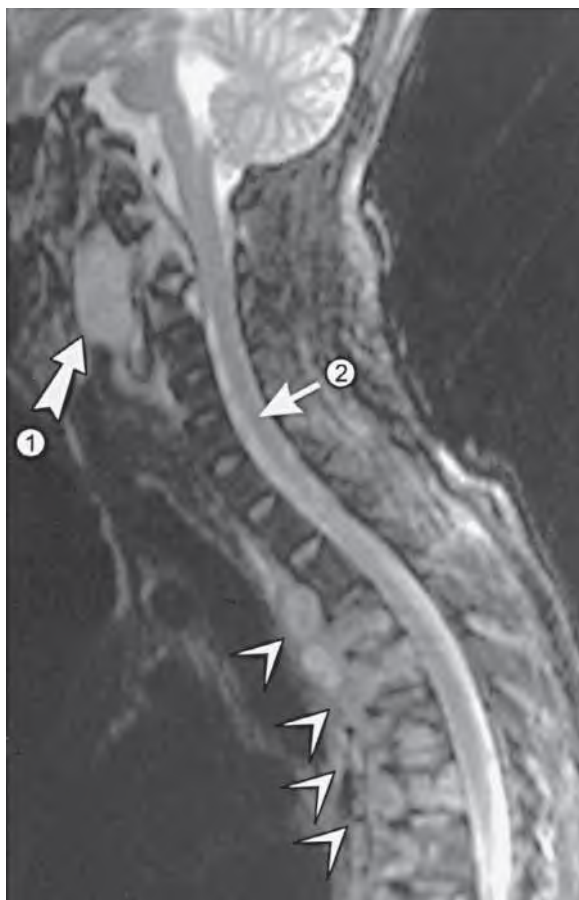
Sagittal magnetic resonance imaging shows an anterior paraspinous abscess extending from the base of the skull to the midthoracic vertebrae. Arrow 1 points to an abscess that originated in a cervical vertebra and dissected anteriorly. Arrow 2 identifies a normal spinal cord. The arrowheads indicate abscesses anterior to the thoracic vertebrae. Multiple surgical procedures were necessary to control this infection.
